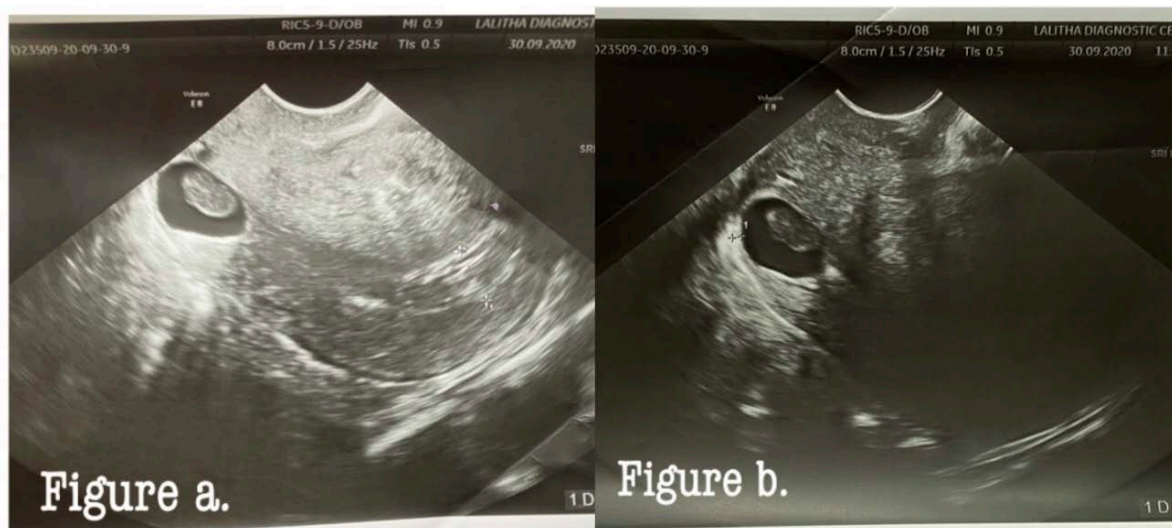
Figure a & b: Ultrasound showing a single intra uterine gestational sac with fetal pole with no cardiac activity on the anterior myometrium at the scar region with empty uterine cavity corresponding to 7-8 weeks of gestation.
